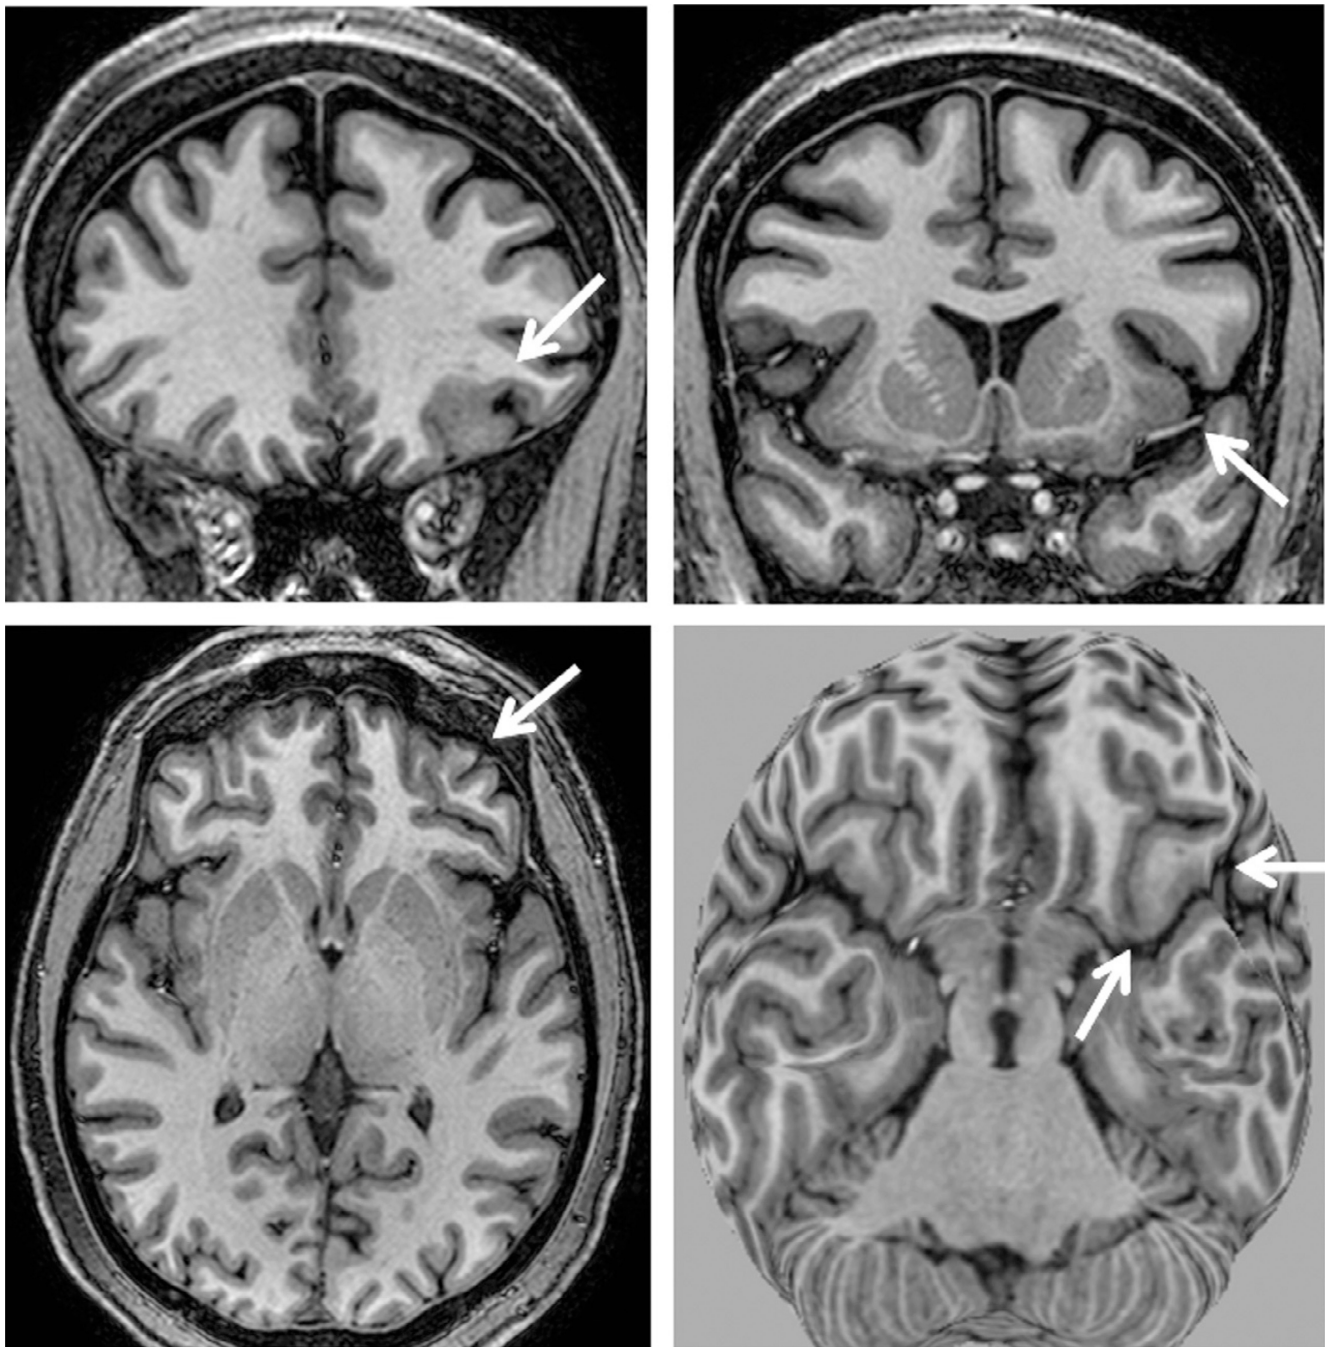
T1-weighted magnetic resonance imaging (MRI) multiplanar (MPR) and curvilinear reconstruction (bottom right) in a patient with frontal-lobe seizures and previous MRIs considered as normal. Note an area with abnormal gyri and slightly thickened cortex and blurred cortical-subcortical transition in the left lateral-basal frontal lobe (arrows). These abnormalities and the focal cortical-subcortical blurring became obvious in the curvilinear reconstructions in layers going from 4 to 8 mm deep from the surface of the brain (bottom right). The T2-weighted and fluid-attenuated inversion recovery images did not show
